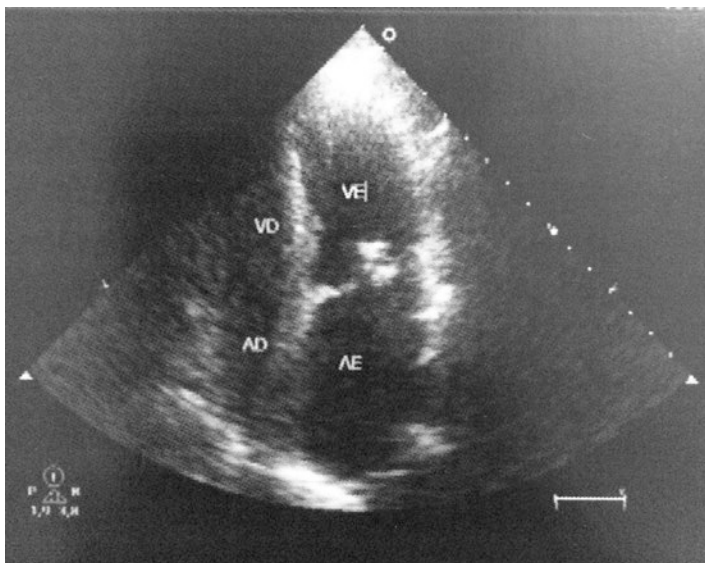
Echocardiography photo of the four cardiac chambers displaying severe mitral valve calcification
